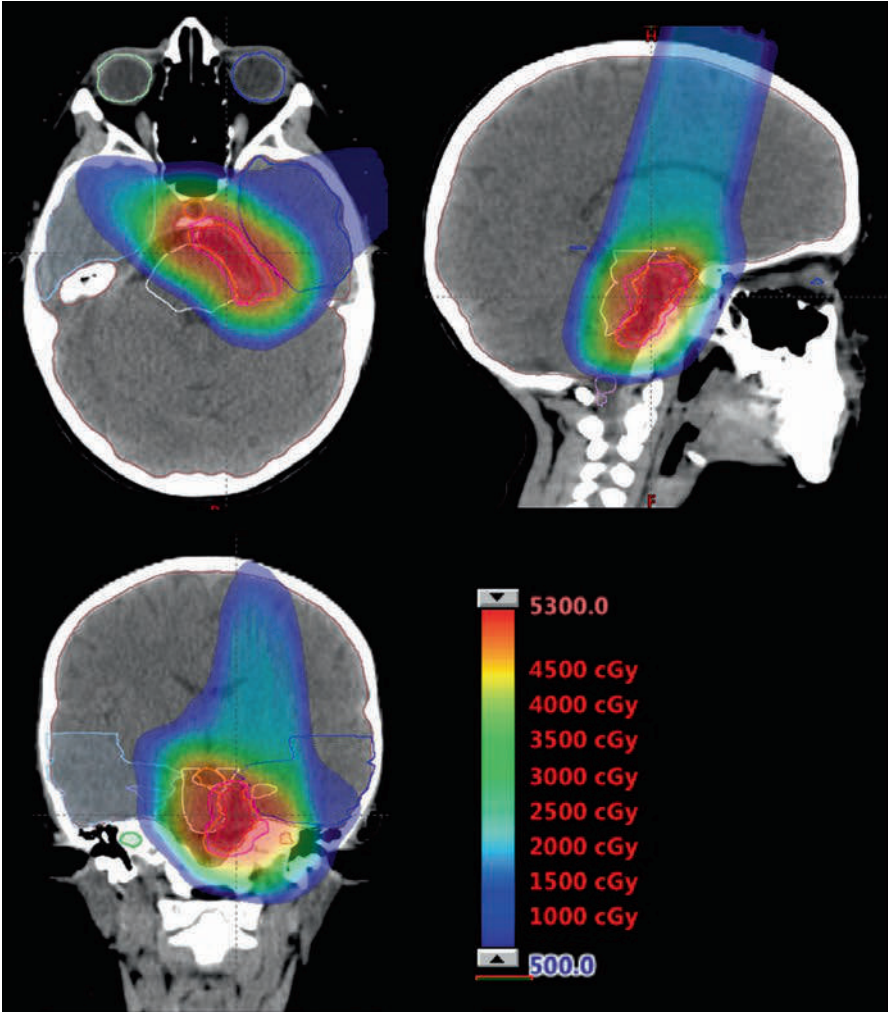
Case 2. Planning CT with target volumes and normal structures delineated
